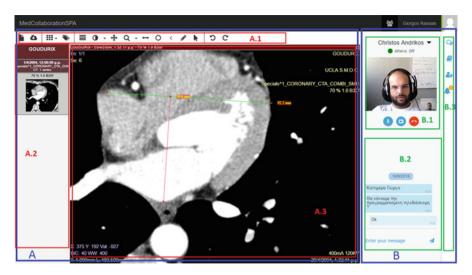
SPA screenshot during a real-time collaborative session on a CT instance between two participants
